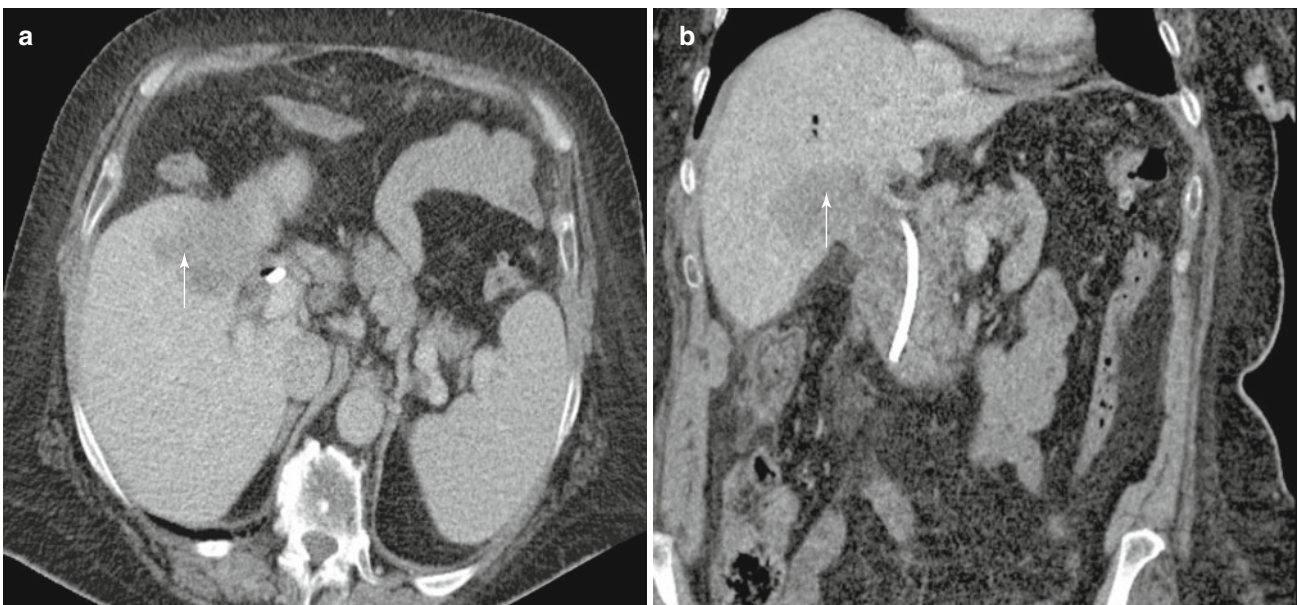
Computed tomographic (CT) scans in the axial (a) and multiplanar reconstruction in the coronal plane (b) from a patient with carcinoma of the gallbladder (*arrow*) filling the entire gallbladder and invading the liver hilum and adjoining right lobe
